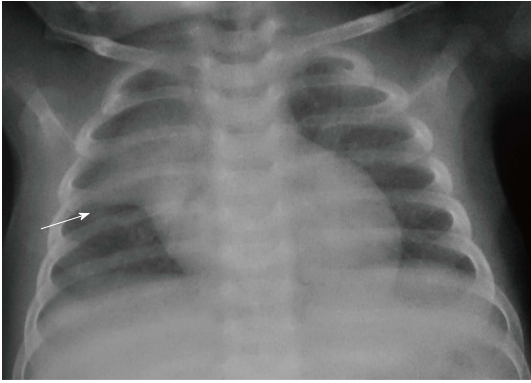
Frontal chest radiograph in an 11-mo-old boy with mild respiratory distress reveals normal thymus with characteristic "sail sign" (arrow).
